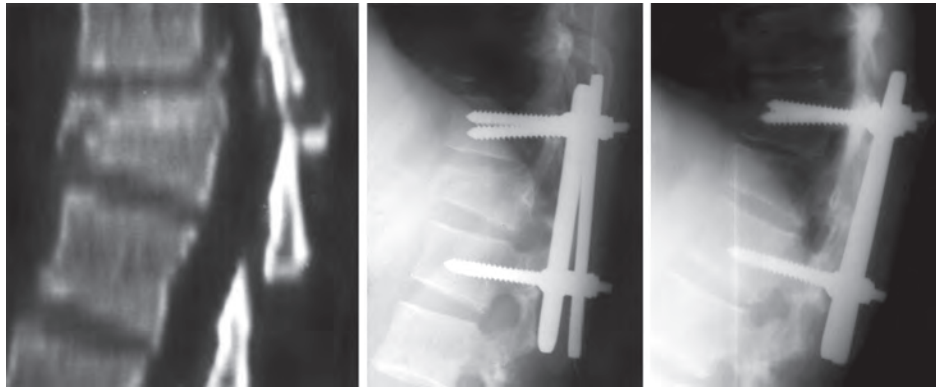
Sagittal reconstructed CT of unstable burst fracture of T12 body treated by short segment Steffee variable screw plate instrumentation (left). Radiograph immediately after surgery (middle) showed moderate correction of kyphosis, which was partially lost in the follow-up film after 5 years (right), even though the patient was asymptomatic
